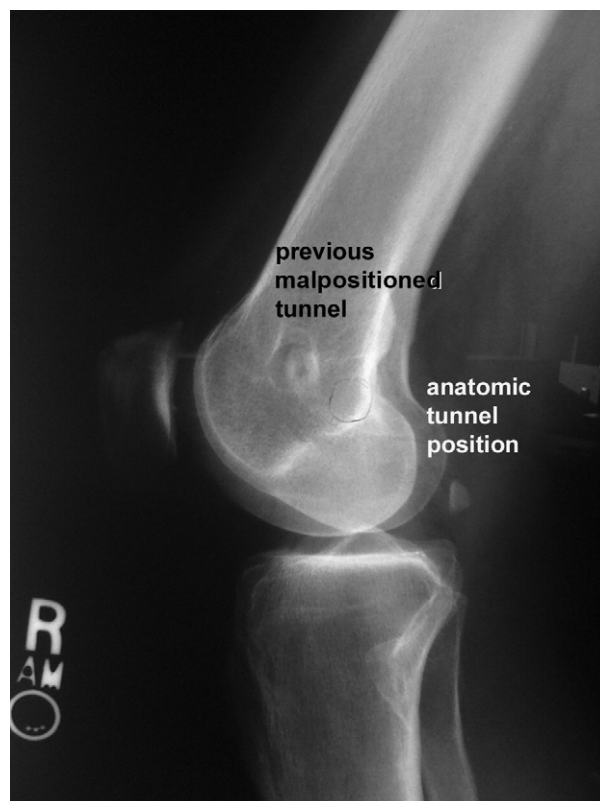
Lateral radiograph showing an anteriorly and proximally positioned femoral tunnel in a 39-year-old woman after an allograft MPFL reconstruction was performed (case 1). Medial patella subluxation and medial patella tilt developed from her malpositioned MPFL graft.
